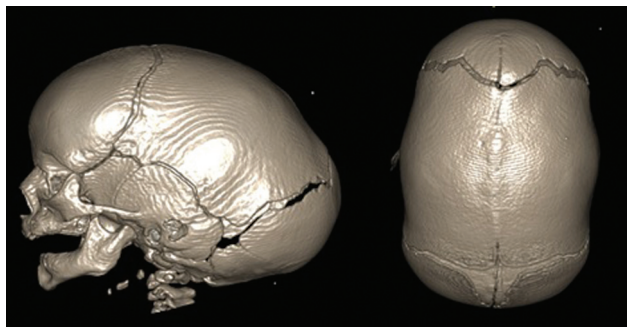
CT scan, 3D reconstruction previous surgery.
